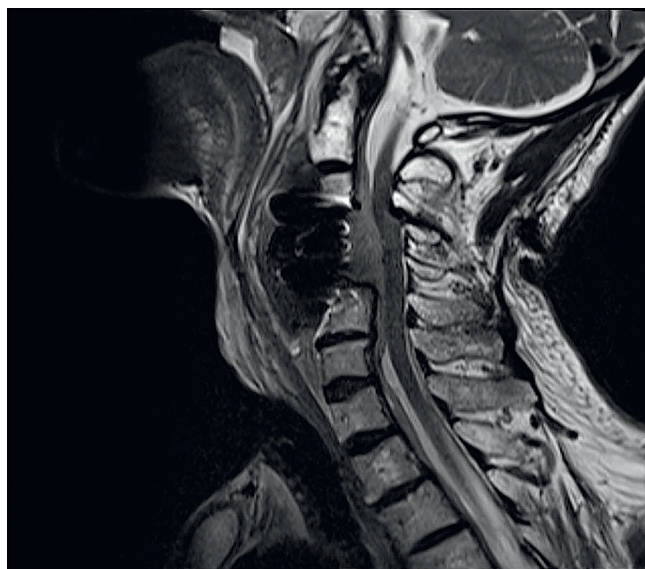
Postoperative T2-weighted cervical sagittal MRI image: The impression of an epidural hematoma extending between C2 and C6 and causing massive cord compression.
